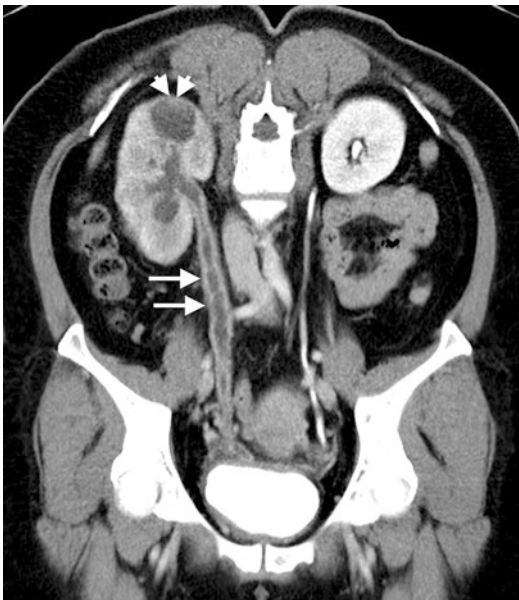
Right renal and ureteric tuberculosis. Oblique coronal CT urography image reconstructed to display the whole length of the ureters shows a long segment of dilated right ureter with irregular wall thickening (long arrows). There is also right hydronephrosis and a large cavity (short arrows) in the right upper pole renal parenchyma. There is no normal contrast excretion into the right pelvicalyceal system. The left kidney, left ureter, and bladder are normal, with normal pelvicalyceal system opacification
